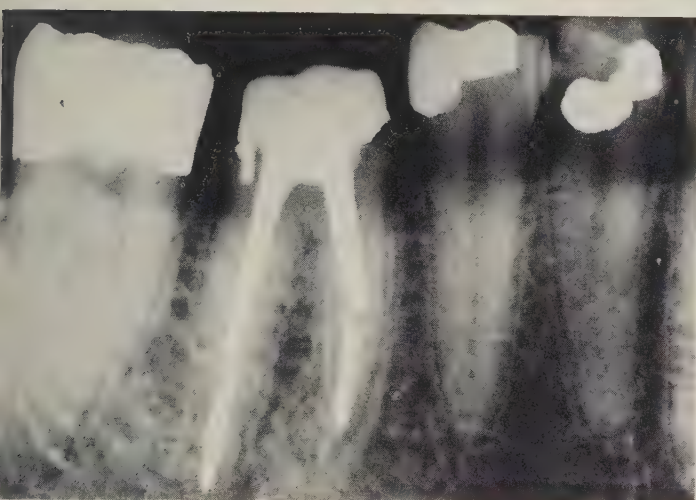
Radiograph of the sectional core and posts of Figure 6 after components were cemented in place.
